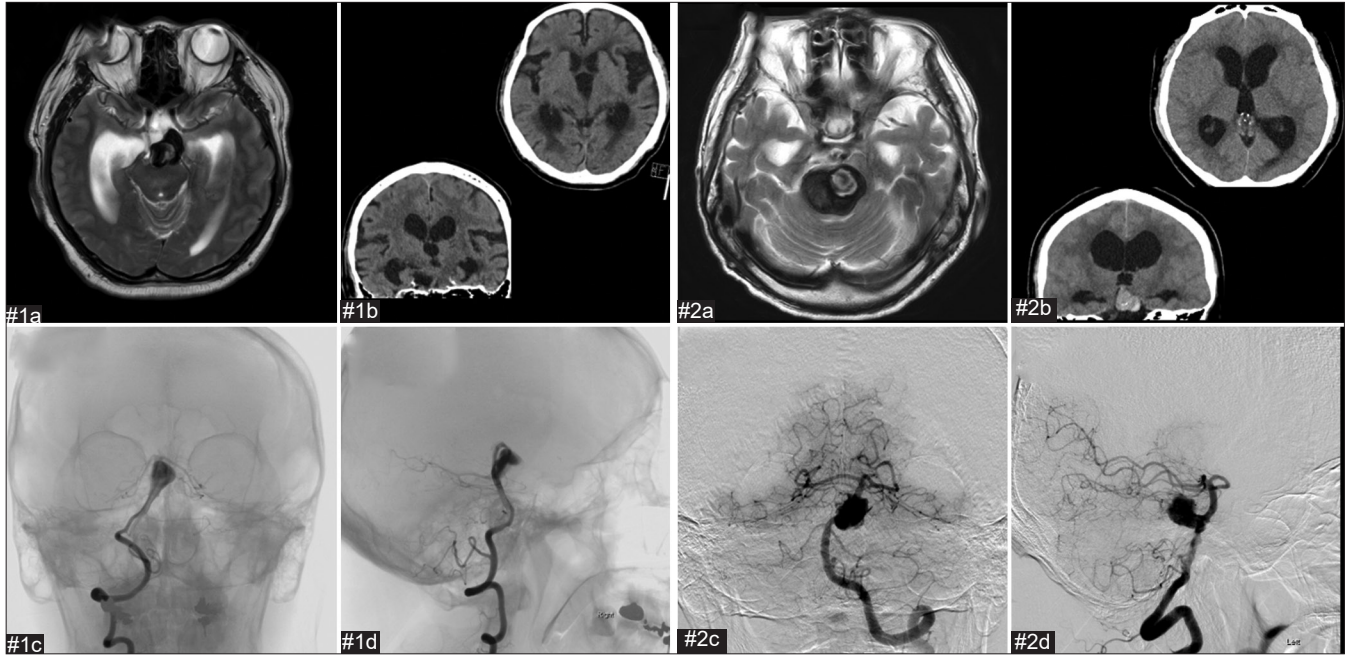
Preoperative images of case # 1 and case# 2. (a) Axial T2-weighted MRI. (b) Axial and coronal CT. Ventricular enlargement with Evans index>0.3, sharpening of the callosal angle, and disproportionately enlarged subarachnoid space hydrocephalus were observed. (c) Frontal digital subtraction angiography (DSA). (d) Lateral DSA.
